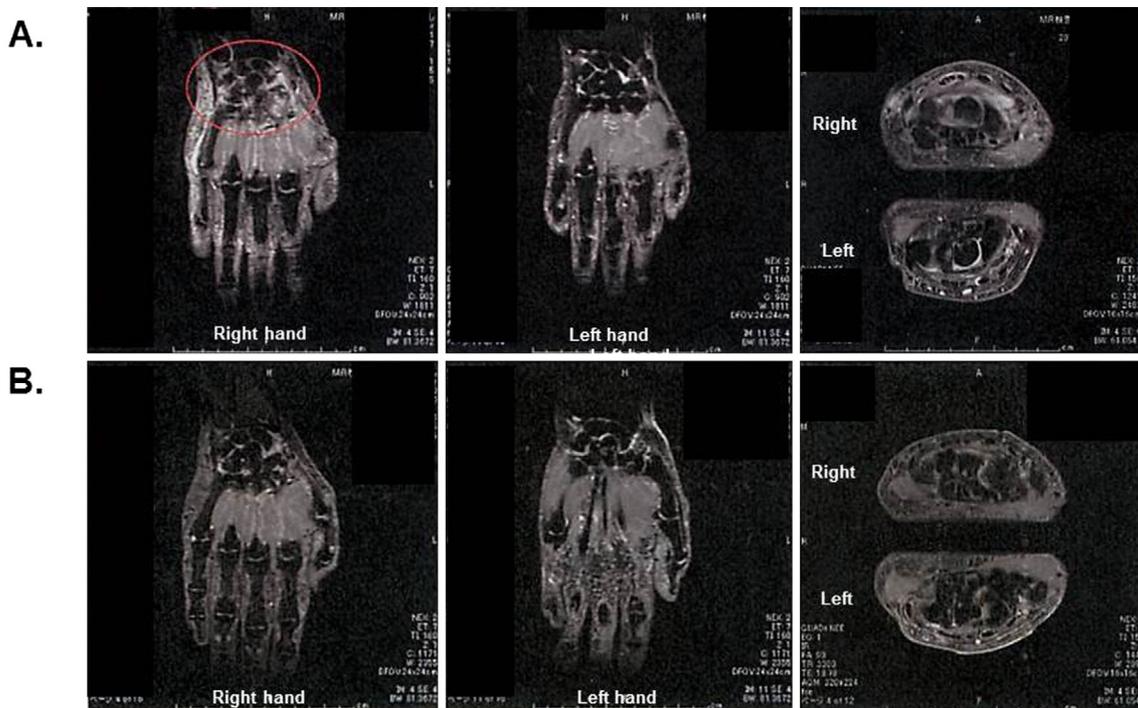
Hand magnetic resonance imaging. A. On admission: Severe synovitis of the right wrist joint, mild synovitis of the left wrist joint and bilateral III-V metacarpal joints and subcutaneous swelling over the dorsum of the right hand and extensor tenosynovitis of the right II-V fingers. B. After treatment: Significant improvements in the tenosynovitis and subcutaneous edema.
